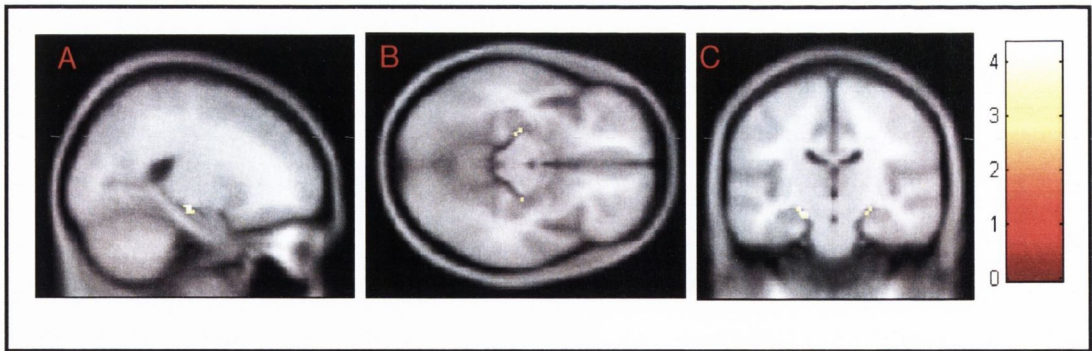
Statistical colour maps showing a significant negative association between grey matter volume in the parahippocampal gyrus bilaterally and the cortisol response to MRI scanning. (A = sagittal view; B = axial view; C = coronal view).
